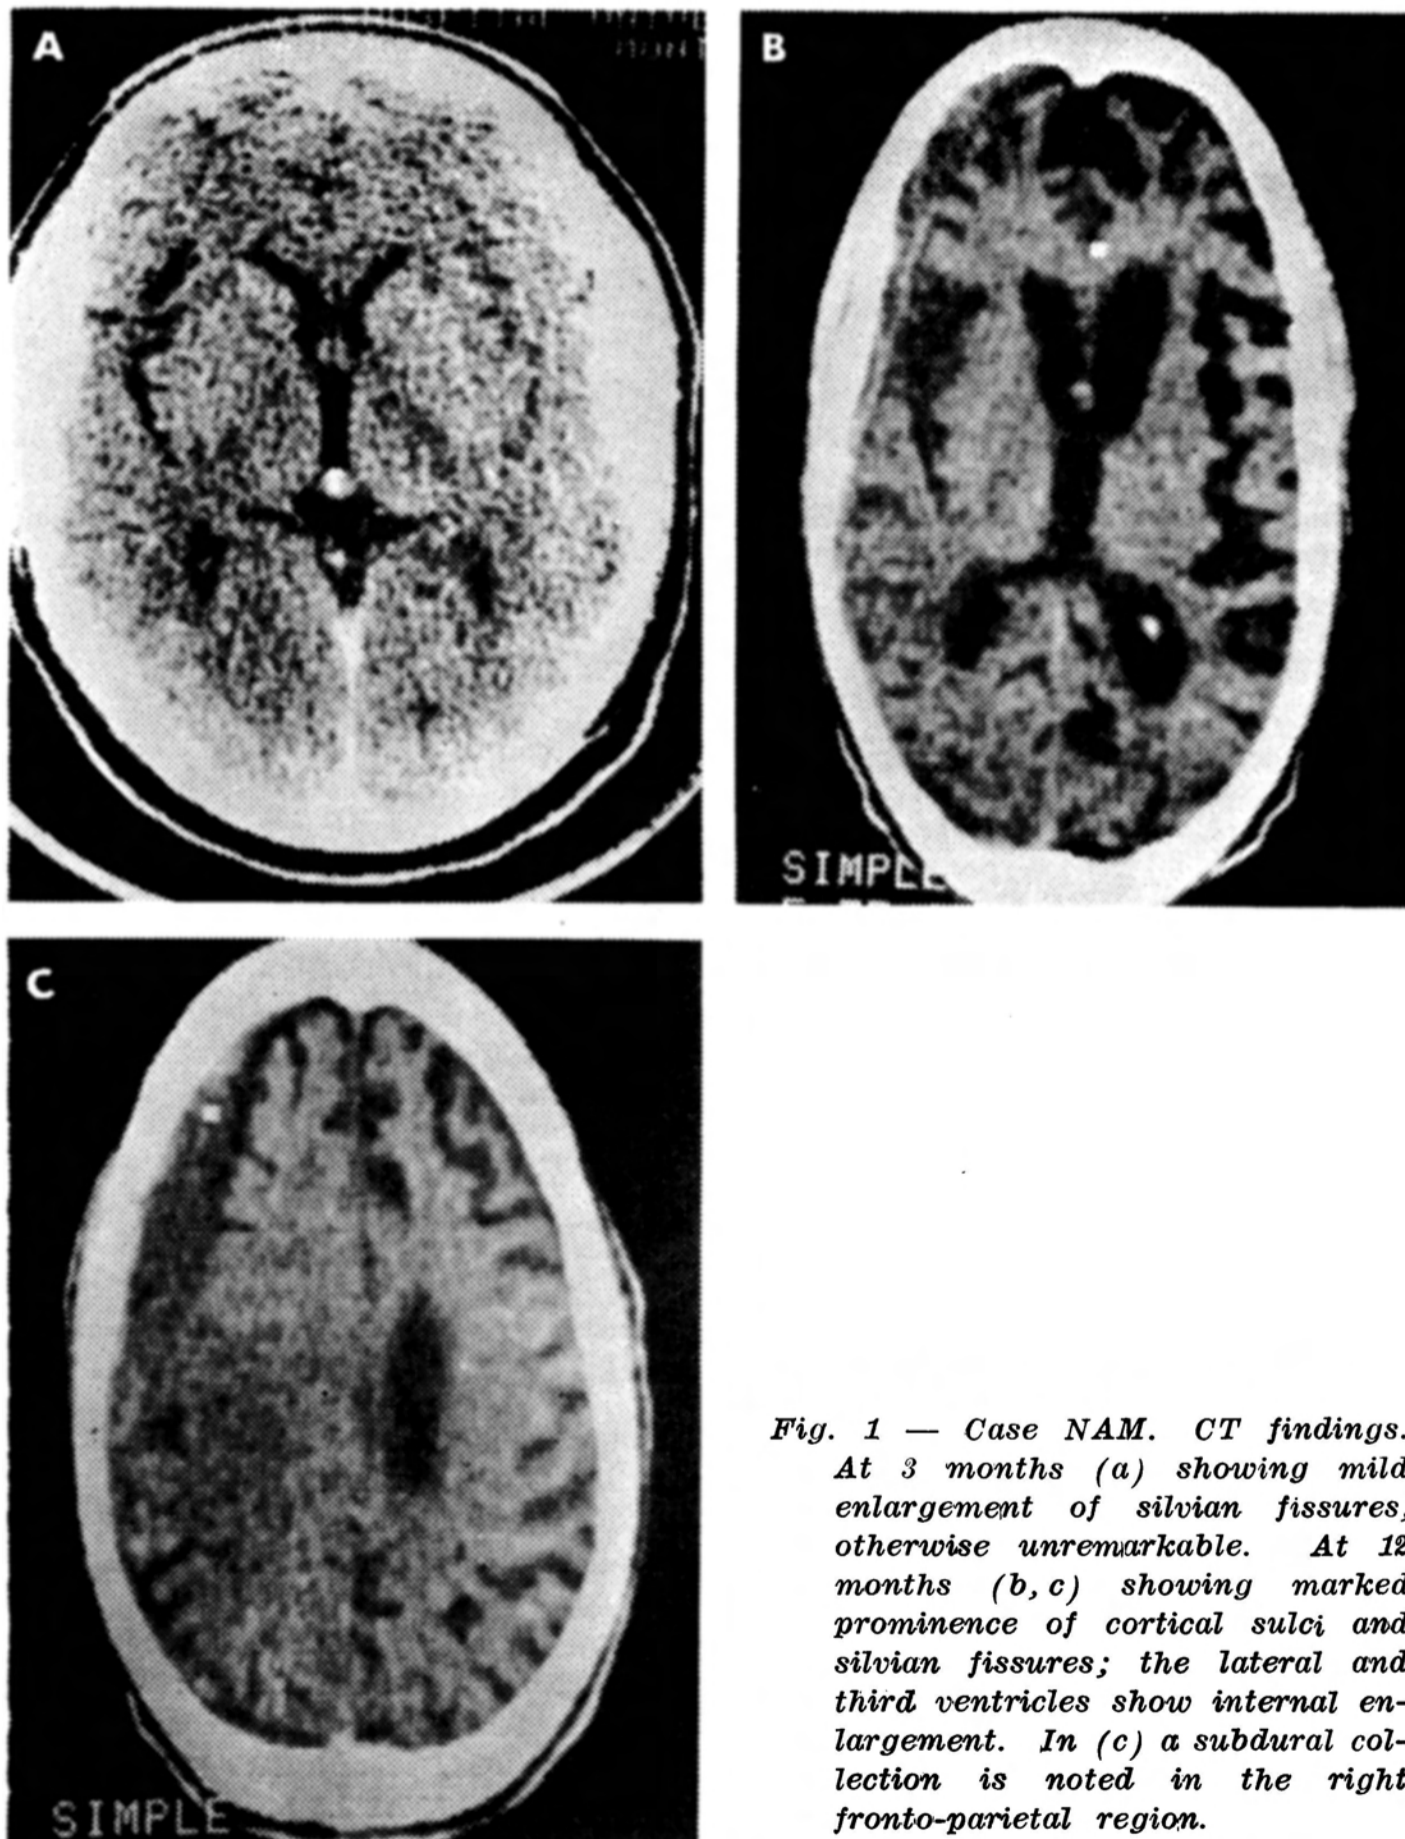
Case NAM. CT findings. At 3 months (a) showing mild enlargement of sylvian fissures, otherwise unremarkable. At 12 months (b, c) showing marked prominence of cortical sulci and sylvian fissures; the lateral and third ventricles show internal enlargement. In (c) a subdural collection is noted in the right fronto-parietal region.
